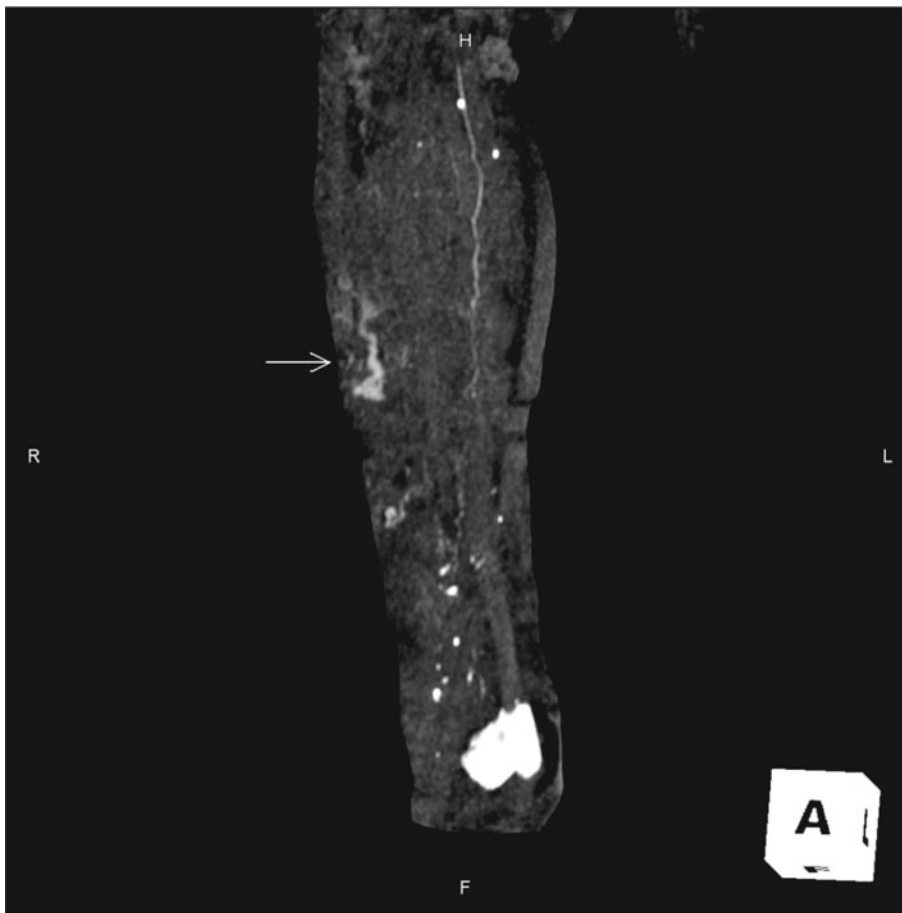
A coronal image from three-dimensional contrast-enhanced CT angiography study performed seven days prior to initiation of radiation therapy. The arrow points to serpiginous vascular structures located mainly in superficial soft tissues of the right leg, which are part of patient's known vascular malformation.
